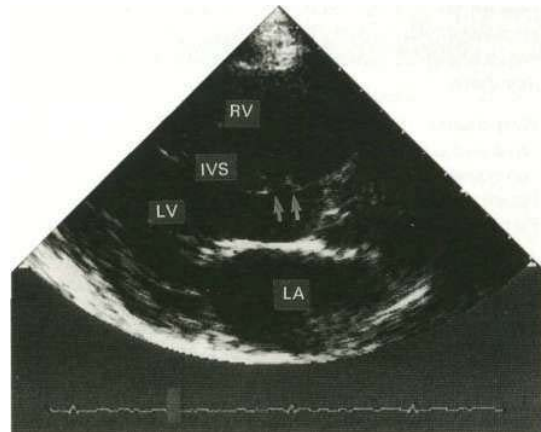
Two-dimensional echocardiogram (long-axis view) showing a ventricular septal defect (arrowed). Colour Doppler would provide graphic demonstration of the left-to-right shunt. RV, right ventricle; IVS, interventricular septum; LV, left ventricle; LA, left atrium.
